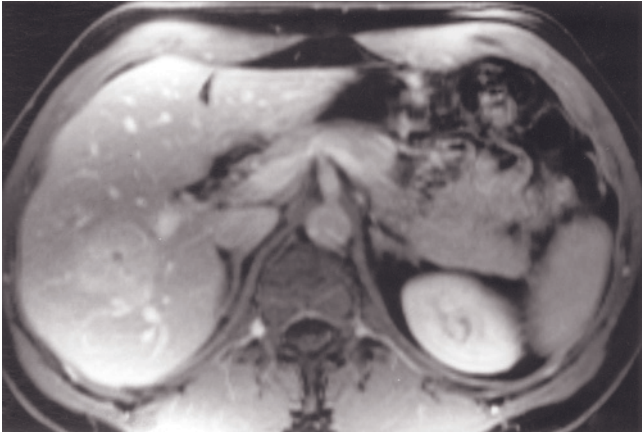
(Continued) Echo train-STIR (*i*), SGE (*j*), and immediate (*k*) and 90-s fat-suppressed (*l*) postgadolinium SGE images in a third patient. There is a lobular lesion in the right hepatic lobe that has minimally increased signal on T2-weighted image (*i*) and near isointensity on T1-weighted image (*j*), demonstrates intense uniform enhancement on the early-phase image (*k*), and fades to near isointensity on the late-phase image (*l*). There is a small central scar best seen as a low-signal linear structure on the immediate postcontrast image (*k*).
